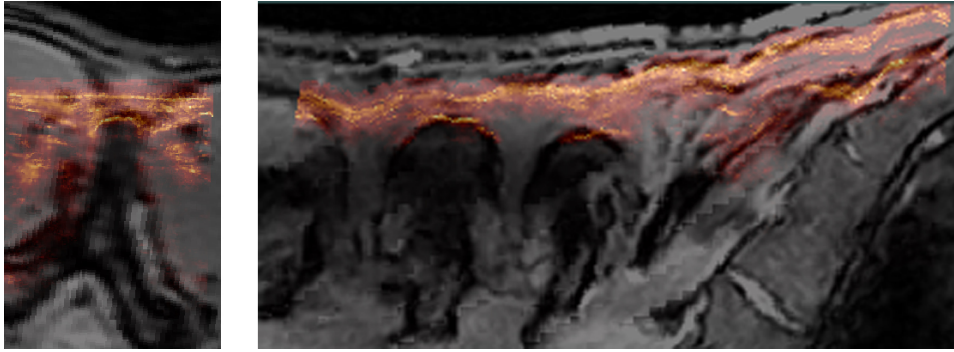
A transverse slice (left) and a sagittal slice (right) from the ultrasound volume overlaid on top of the corresponding slices from the registered MR volume. The ultrasound data is shown in red and yellow and the MR data is shown in grey tones.
